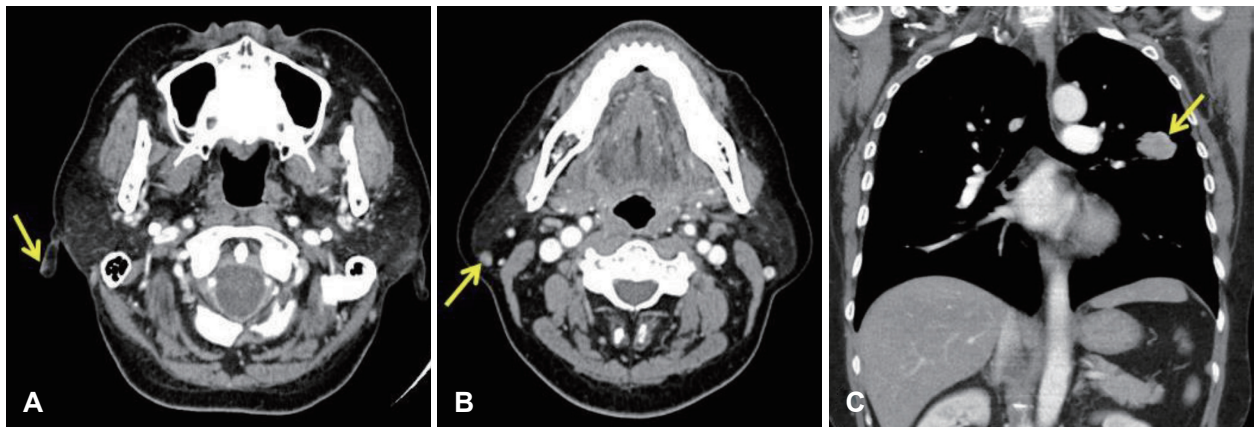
Computed tomography examination for cancer evaluation. A: Temporal bone computed tomography showed no definite lesion of right ear after initial excisional biopsy (arrow). B: Temporal bone computed tomography revealed 7×5-mm enhancing lymph node in the right parotid gland (arrow), suggestive of metastatic lymph node. C: Chest computed tomography revealed about 3.5 cm-sized mass with irregular shape, spiculated margin, and homogenous contrast enhancement in the left upper lung (arrow), suggestive of lung cancer such as adenocarcinoma.
